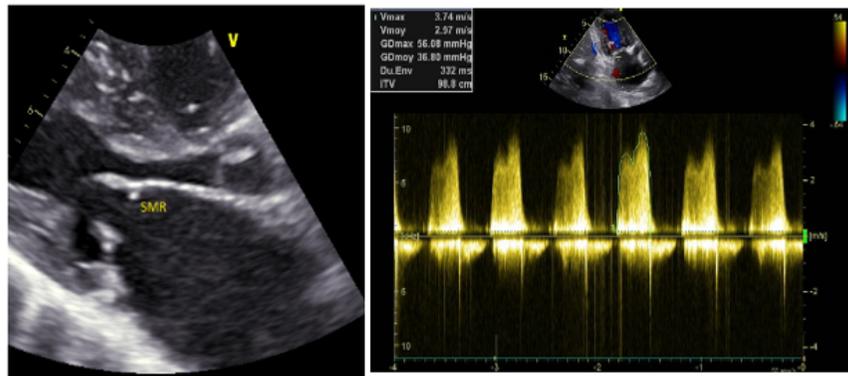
2-D Long-axis view in diastole showing the SMR and Continuous Doppler quantifying the peak and mean trans mitral valve gradients.
